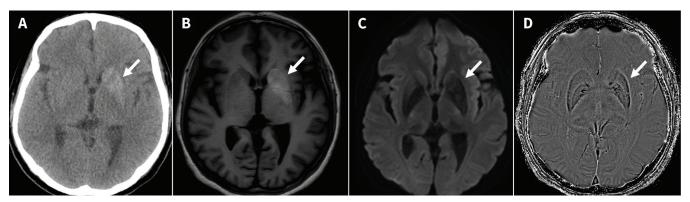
Brain imaging of a 45-year-old woman with right hemichorea. (A) Plain computed tomography showed asymmetric hyperdensity in the left striatum (arrow). (B) T_1 -weighted magnetic resonance imaging showed high signalling in the corresponding region (arrow), without restricted diffusion. Diffusion-weighted imaging (C) and susceptibility-weighted imaging (D) confirmed no restricted diffusion (i.e. acute infarct) and no hemorrhage in left striatal lesion (arrow).
